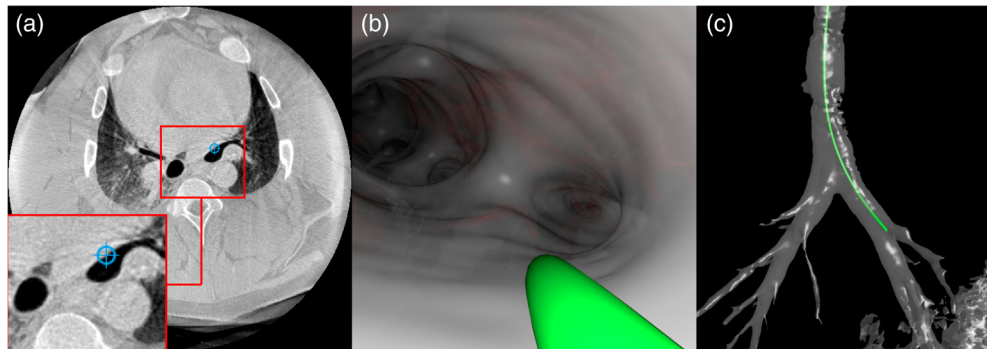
Three different visualization techniques for device navigation based on CLA reconstruction showing the same time frame: (a) axial view through the CBCT volume with the device tip shown with blue cross hairs (inset shows a magnification of the region with the device), (b) virtual endoscopic view with device shown as a green tubular structure (virtual camera placed just behind the device tip), (c) 3D rendering with a semi-transparent airway surface and the device shown as a green tubular structure.
